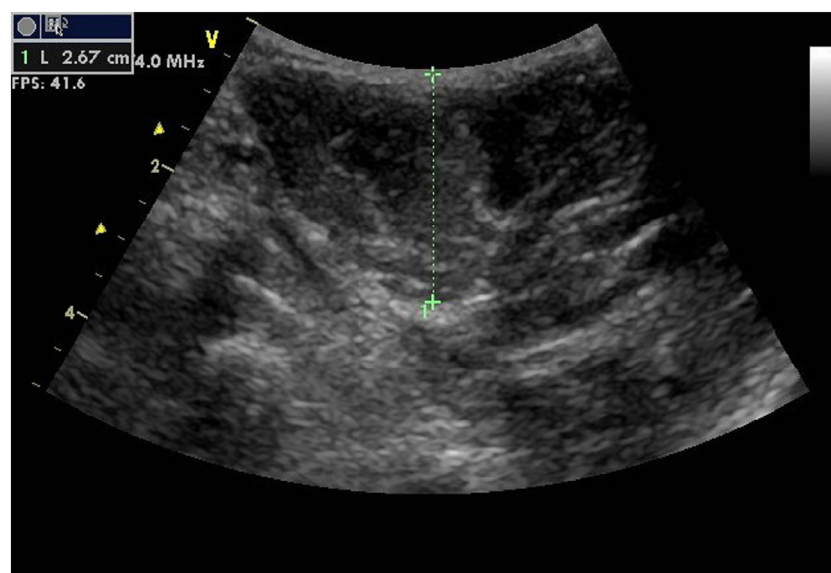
Ultrasound measurements of the pronator teres.*
